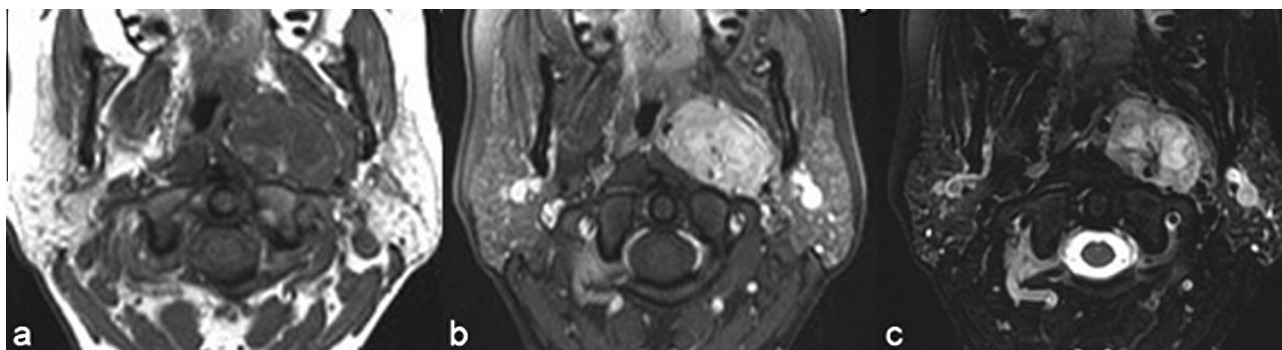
Axial T1-weighted (a), T1-weighted post-contrast (b), and T2-weighted MRI with fat saturation (c) of a representative left carotid body tumor showing a salt-and-pepper appearance with avid arterial enhancement.
